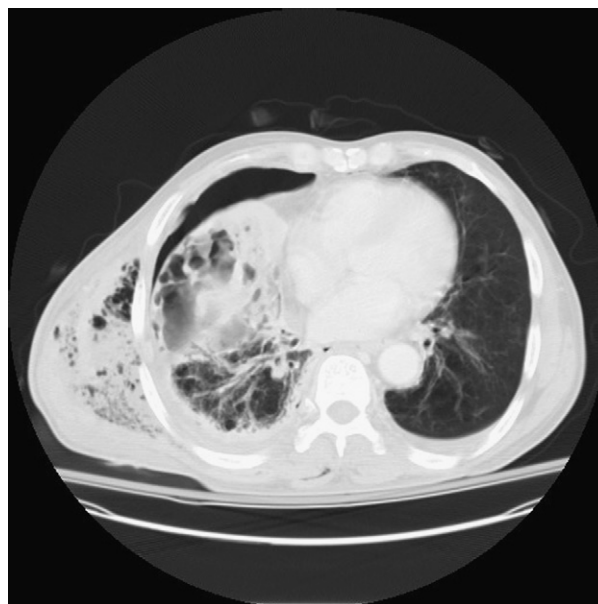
Chest computed tomography shows necrotizing pneumonitis change of the right middle and lower lobe, pleural thickening with hydro-pneumothorax, and amorphous fluid and air accumulation over chest wall.
